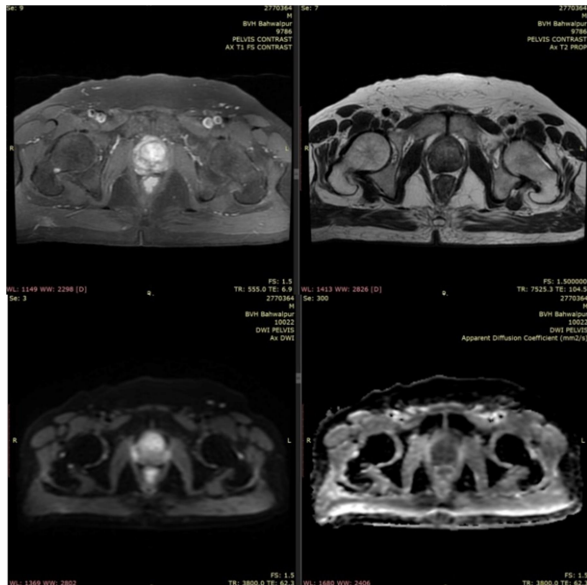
Figure showing abnormally enhancing lesion involving prostate gland on T1 post contrast study with restricted diffusion on DWI and low ADC value
